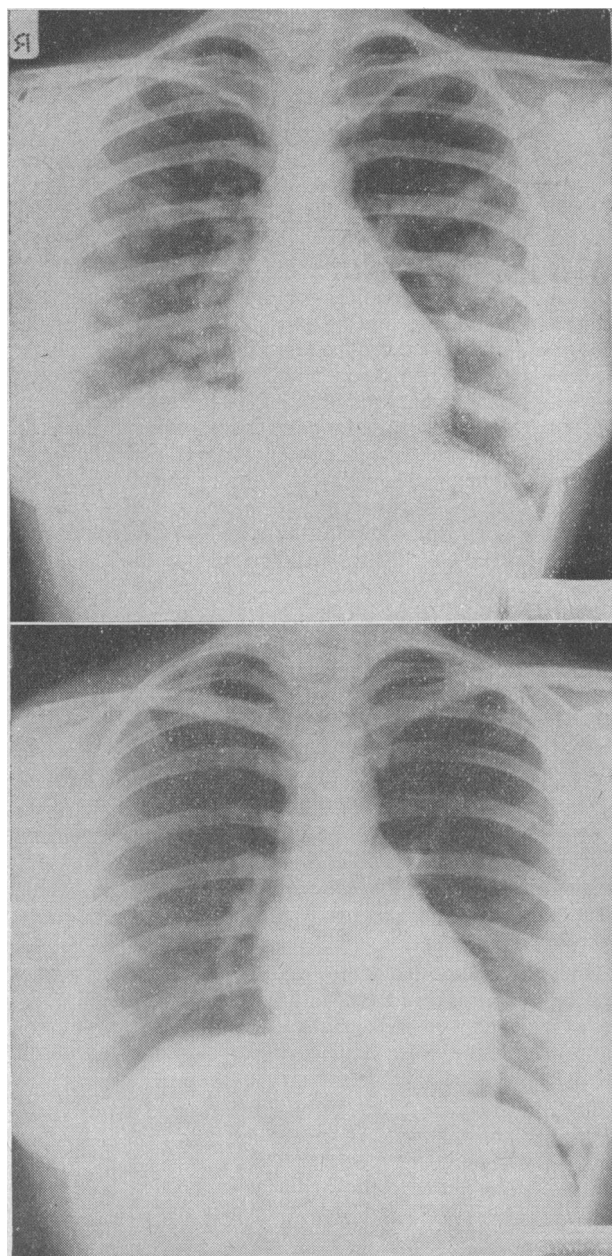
Case 5. Top: Chest x-ray film taken on May 17, 1959, showing multiple metastases in both lung fields. Bottom: Chest x-ray film taken on November 10, showing complete radiological resolution.
